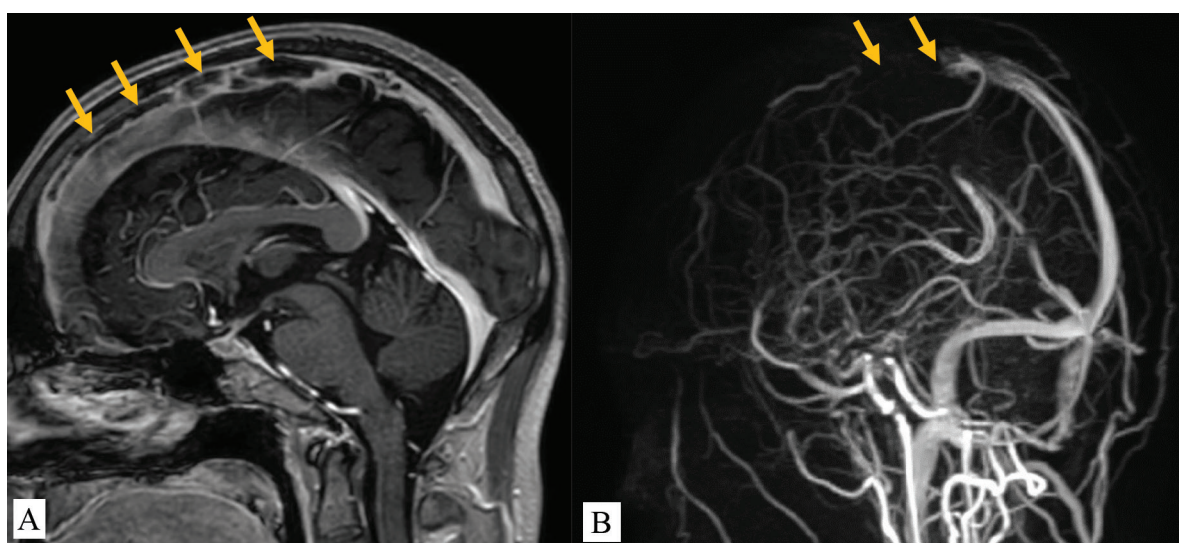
(A) Brain MRI -T1WI with contrast showed loss of contrast opacification (arrows) due to thrombosis of anterior and mid segment of superior sagittal sinus. (B) MRV study shows loss of signal void (arrows) in anterior and mid part of superior sagittal sinus.
